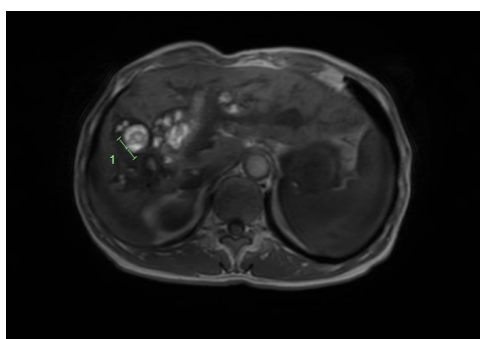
MRI T1 axial images of a 2 cm right intrahepatic duct calculi.
